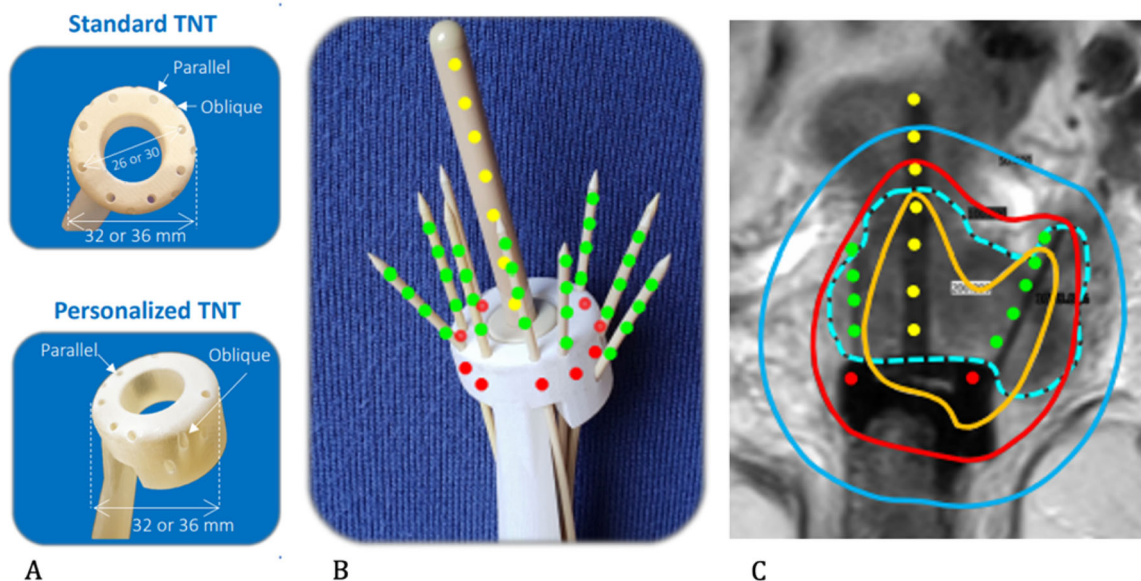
(A) Standard and personalized tandem-needle-template [TNT], with corresponding diameters and needle holes for parallel and oblique needles; (B) Personalized TNT fitted over the Varian tandem with both parallel and oblique needles *in situ*; (C) the tandem and personalized TNT with needles on MRI in coronal view showing oblique and parallel needle position (green dots), stopping positions in the tandem (yellow dots) and at ring level (red dots), CTV_{HR} (blue dashed line) and isodose distribution (yellow 200%, red 90%, blue 50%).
